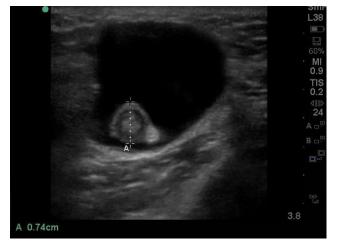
Short axis view ultrasound of an inguinal mass.
